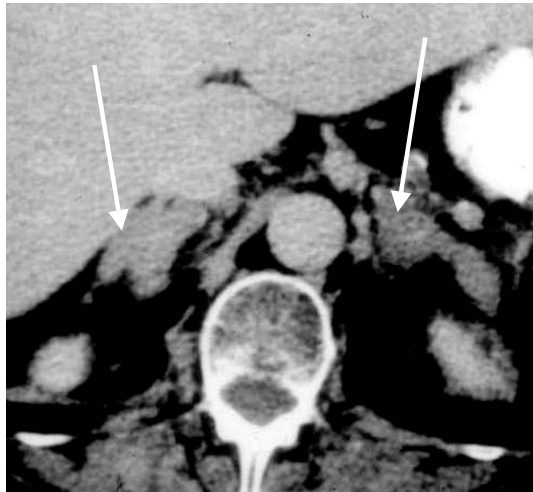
Bilateral adrenal cortical hyperplasia. Axial contrast-enhanced CT image shows nodular thickening of adrenal glands bilaterally in patient with Cushing's syndrome.
